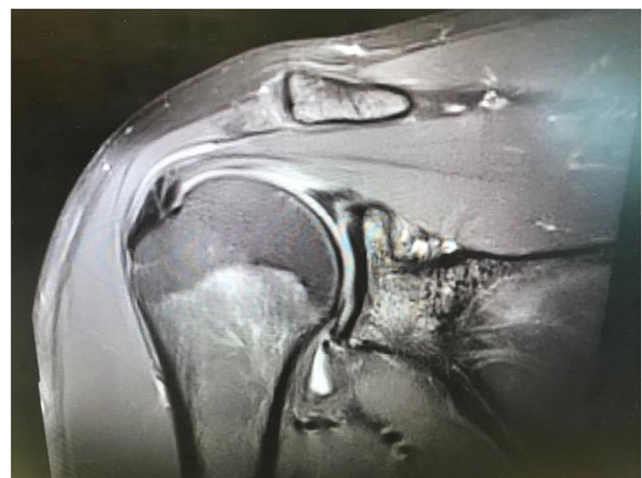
Coronal view of a MRI showing a superior labrum consistent with a superior labrum anterior and posterior (SLAP) tear
